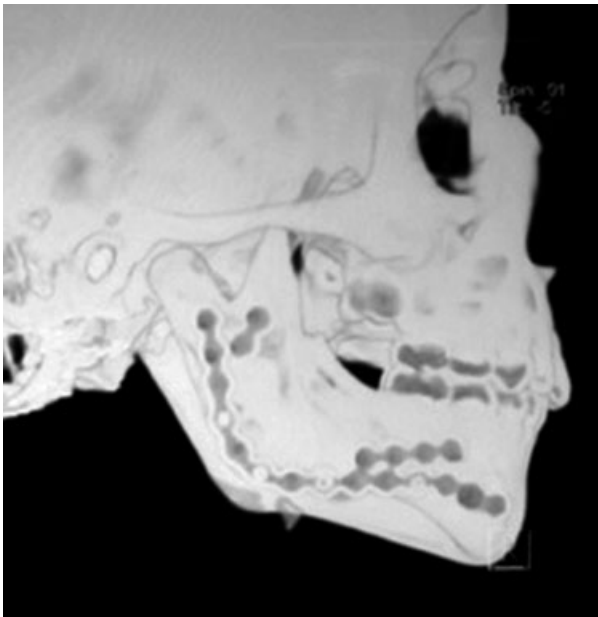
The good adaptation and mandible arch of miniplates can be observed in the computed tomography.
